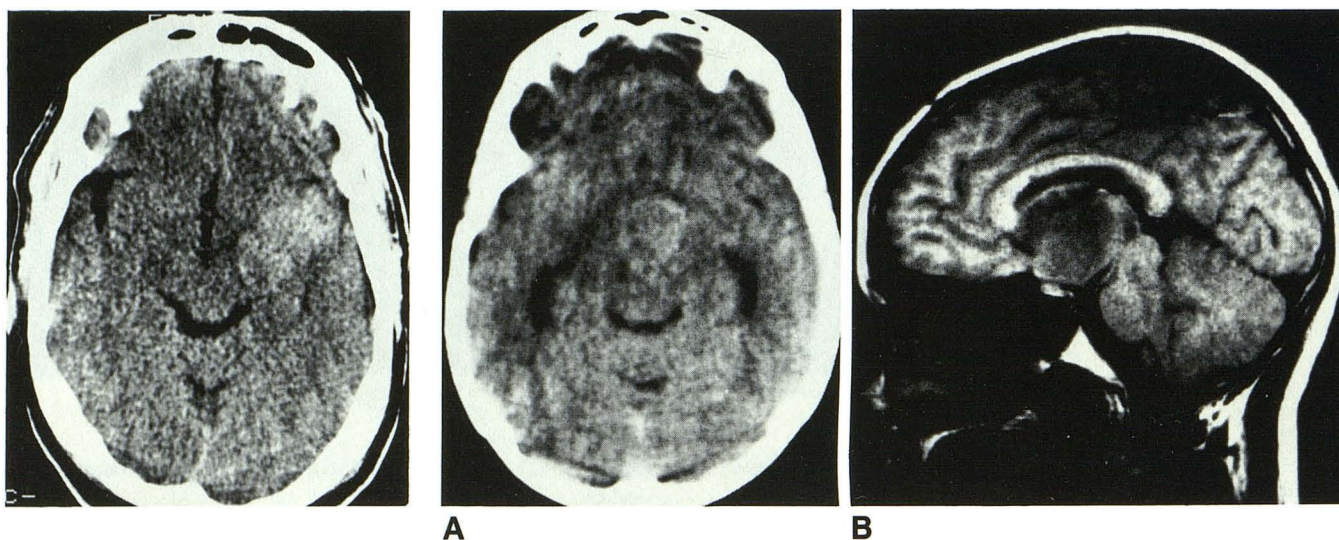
Case 4. Noncontrast CT scan shows hyperdense, ill-defined mass in left temporal lobe. There is mass effect upon ipsilateral sylvian fissure. Tumor did not enhance after IV administration of contrast medium.
